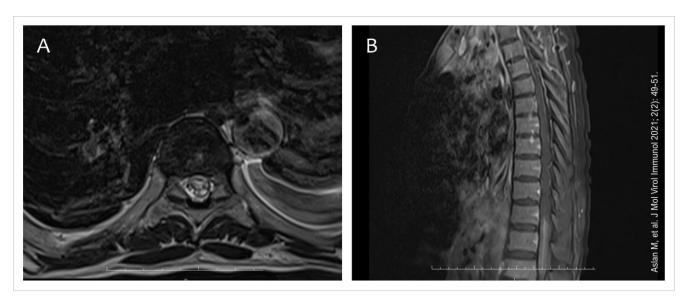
(A) Axial T2-weighted magnetic resonance image shows intramedullary hyperintensity occupying greater than two-thirds of the cross-sectional area of the spinal cord. (B) Contrast-enhanced T1 weighted sagittal magnetic resonance image reveals diffuse enhancement of spinal cord at T10-L1 level.
